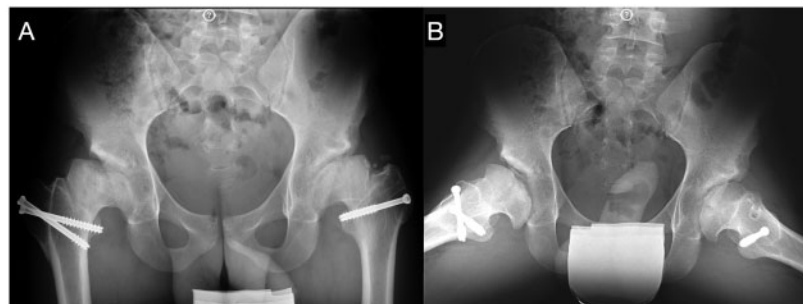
Anteroposterior (A) and axial (B) radiographs of both hips after the surgical procedures. Trochanteric osteotomies radiographically healed in a more distal position, femoral heads reshaped to achieve a more spherical morphology and a transitional head-neck junction and the osteochondral autografts appeared to be well incorporated.
